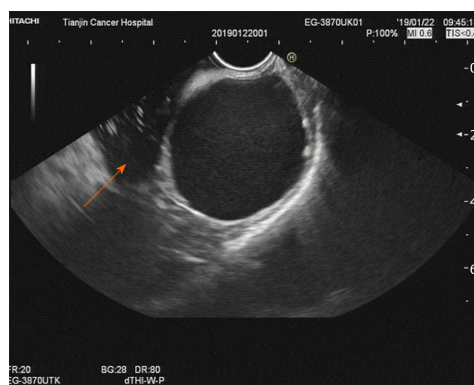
Imaging at admission. An endoscopic ultrasound examination showed a 45 mm × 49 mm single cyst originating from the gastric submucosa (arrow). It also revealed that the cyst, without any echoes or color flow signals, was located in the posterior wall of the fundus close to the cardia. These results indicated the possibility of cystic hygroma of the stomach.
